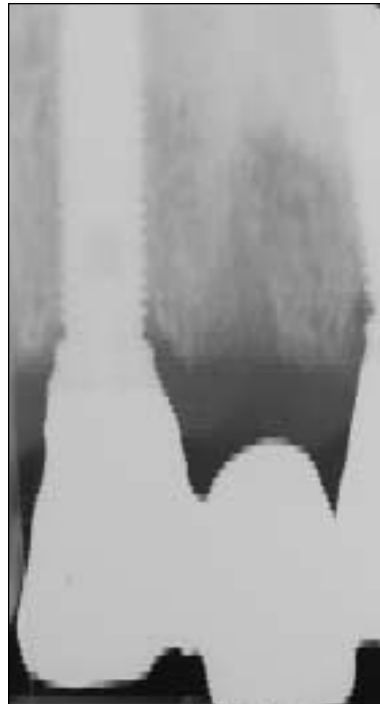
(Right) Radiograph taken at the implant in the maxillary right lateral incisor position shows apparently good framework fit.
